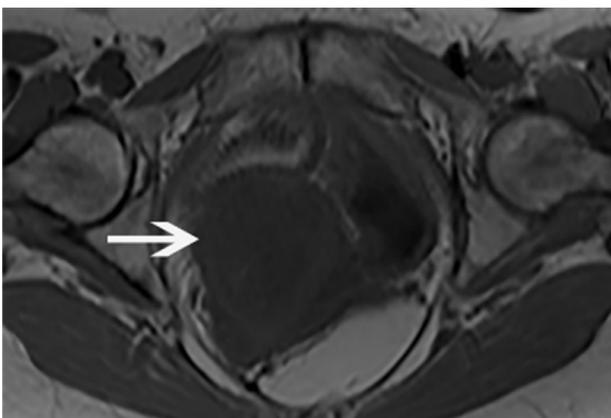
Axial T1-weighted MRI image shows UCS (white arrow) has similar signal intensity to the myometrium. UCS, uterine carcinosarcoma.
